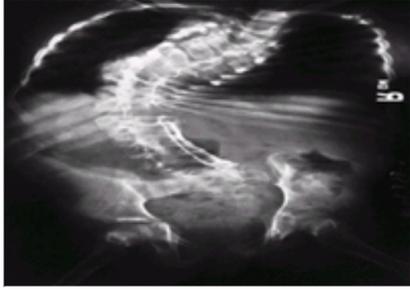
Multiple pterygium syndrome in a 13-year-old patient. Radiograph shows severe scoliosis, vertebral abnormalities, and an unsegmented bar from T9 to T12 and from L1 to S1, with an apparent gap between the bars. (From ref. [1](#), with permission.)
